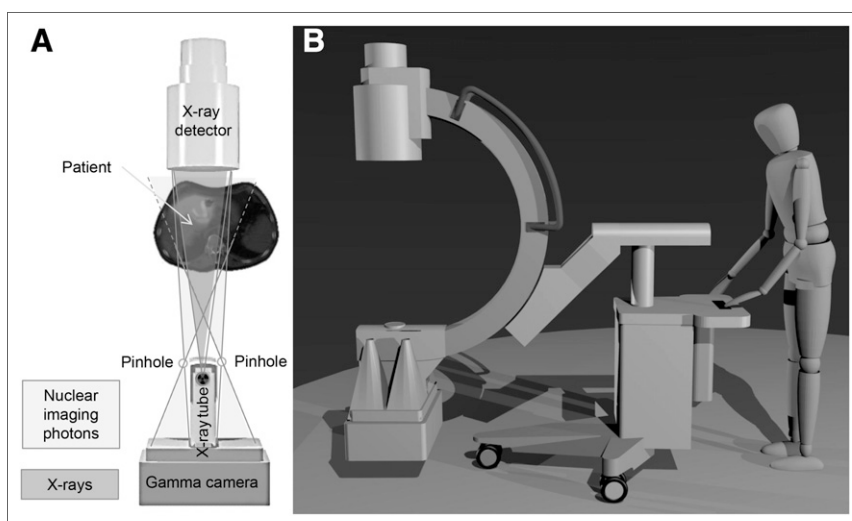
(A) Hybrid C-arm showing field of view of pinhole collimator and x-ray photons. (B) Entire system (50).
